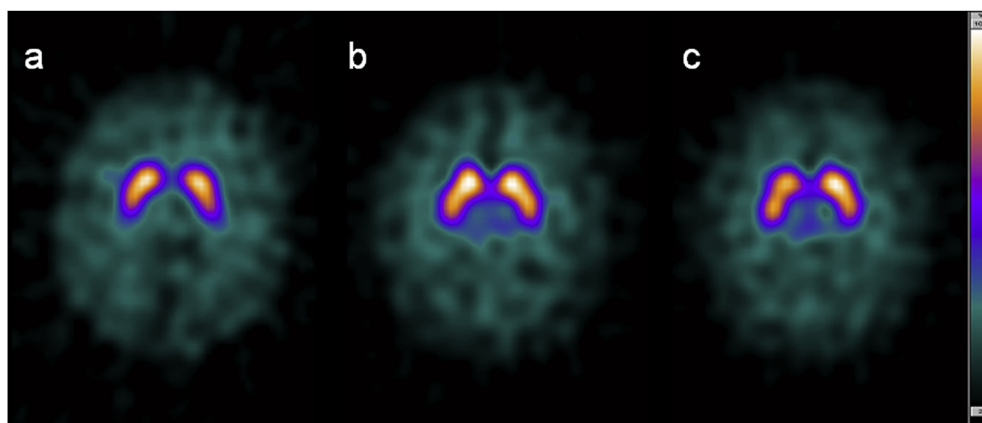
Transaxial SPECT images (slice thickness: 3.9 mm) showing ^{123}I -FP-CIT uptake in the bilateral striatum of an age-matched healthy subject (a) and an AUD patient before (b) and after (c) 1 month of real rTMS sessions. At baseline assessment, an increased radiotracer uptake (i.e., higher DAT availability) was observed in the bilateral striatum of the AUD patient as compared with the healthy subject. After rTMS treatment, a reduction of striatal radiotracer uptake was detected.
